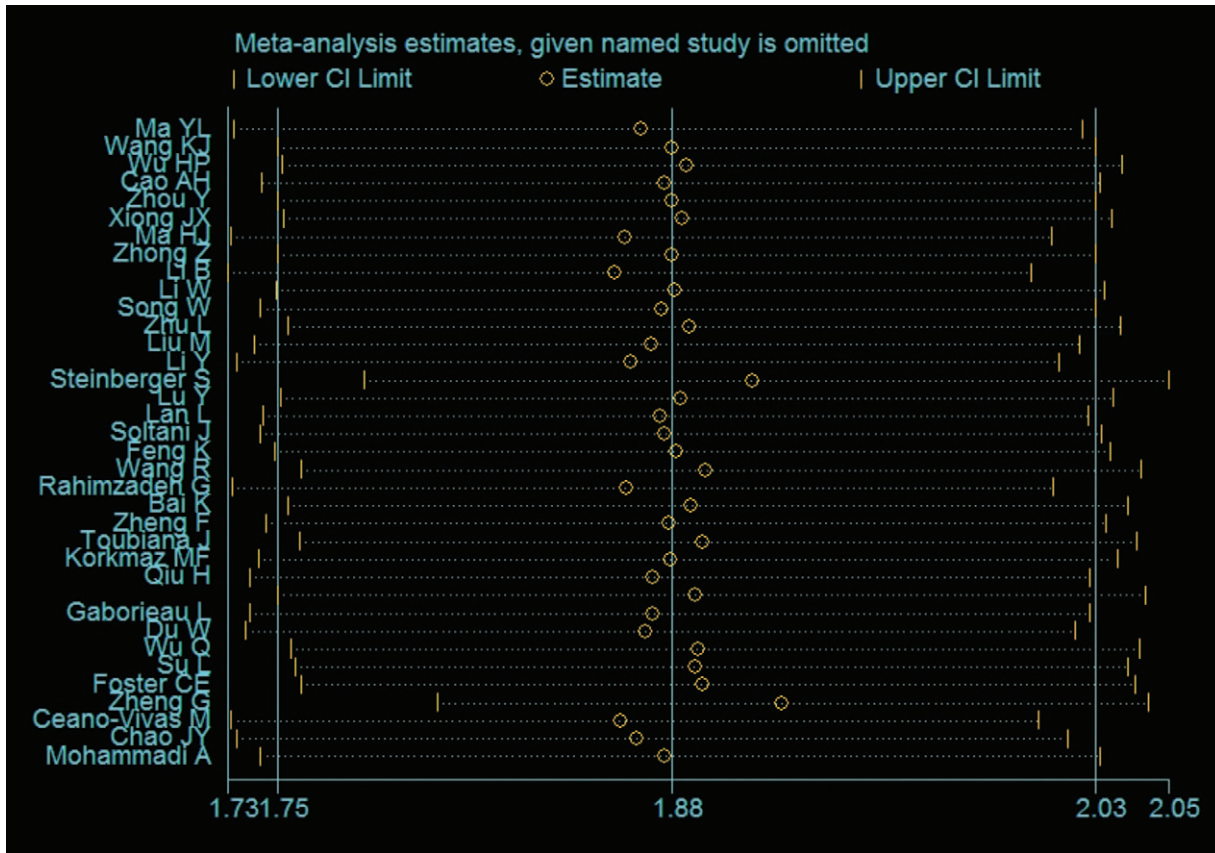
Sensitivity analysis of abnormal CT. CI = confidence interval, CT = computed tomography.
